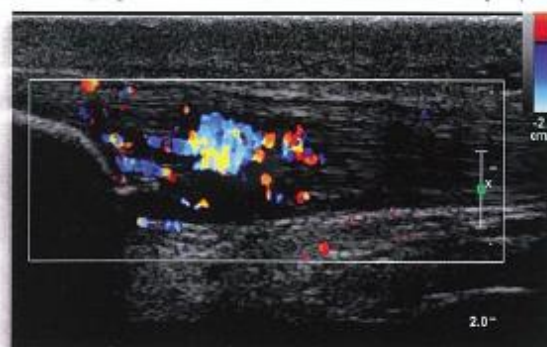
Ultrasound of a patella tendon demonstrating changes fitting with dysrepair/degeneration (note the vessels evident on power Doppler, hypoechoic areas and the tendon swelling).
